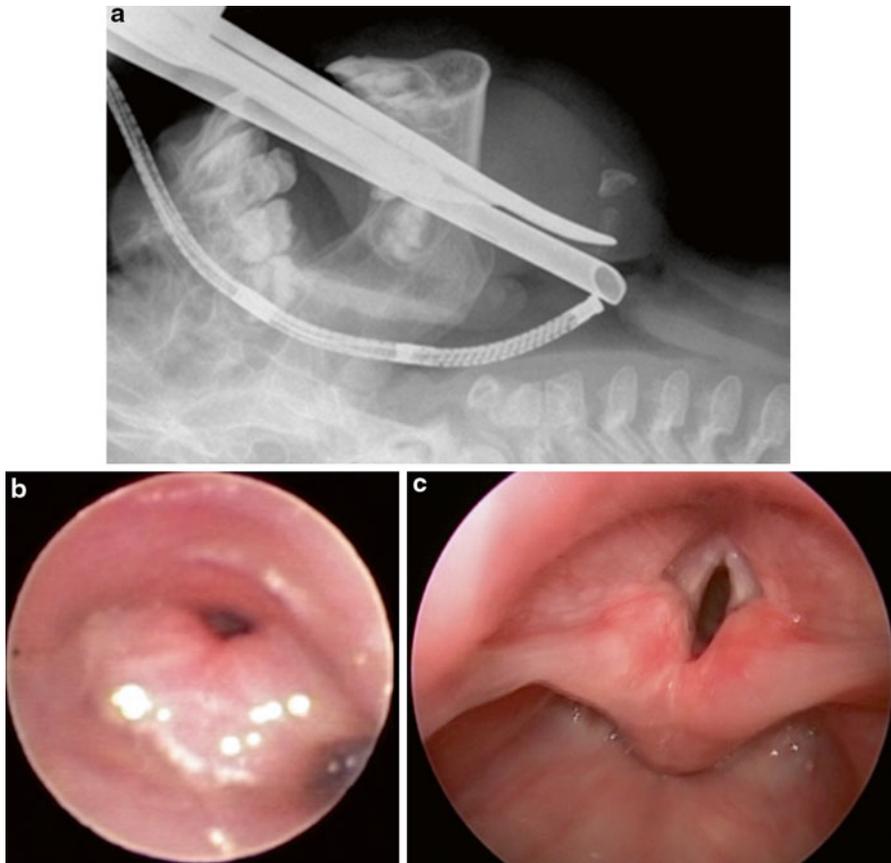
Flexible and rigid instruments approach the larynx from very different perspectives. A rigid instrument necessarily elevates the hyoid and tongue base, lifting and distorting the larynx, while at the same time allowing more detailed anatomic evaluation as well as manipulation of the tissues under direct vision. The flexible instrument, on the other hand, approaches from behind, and is much more suitable for evaluation of laryngeal dynamics. When there is any suspicion of posterior laryngeal pathology (laryngoesophageal cleft, for example) both instruments may need to be employed in order to obtain a full understanding of the laryngeal anatomy and dynamics. (a) Lateral radiograph showing the path taken by rigid and flexible instruments. Note the elevation of the hyoid and tongue base by the rigid instrument and the angle of approach to the larynx by both instruments (this is not the same patient as in b and c). (b) The larynx of a child with a history of inspiratory stridor, seen by a flexible instrument. There is no traction on the larynx, and in this view, the mucosa overlying the arytenoid cartilages completely obscures the view of the glottis, and produces significant inspiratory obstruction. (c) The same larynx as seen by a rigid instrument. The larynx is being elevated by a rigid laryngoscope. The mucosa, which through the flexible instrument looked redundant and possibly edematous, now looks anatomically normal, and there is no obvious obstruction
